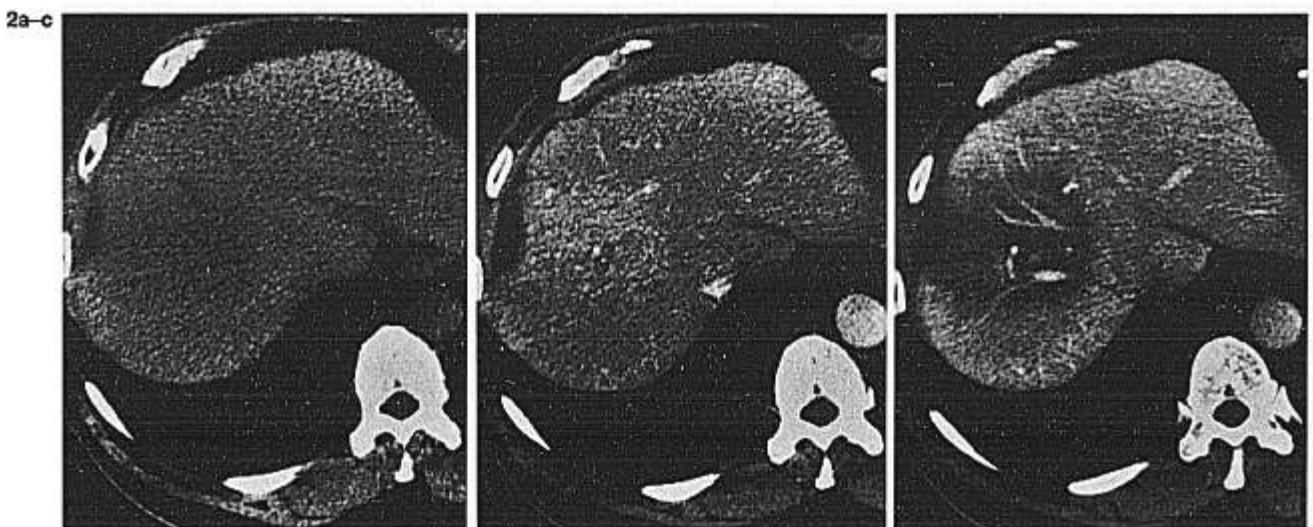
Oval-shaped attenuation difference demonstrated on CT scans 3 months after proton radiotherapy. The target volume irradiated to a high dose is seen as a hypodense vague contour on a noncontrast CT scan (a), hyperdense on arterial dominant phase dynamic CT scan (b), and hypodense with a definite boundary on CT scan during arterial portography (c).
